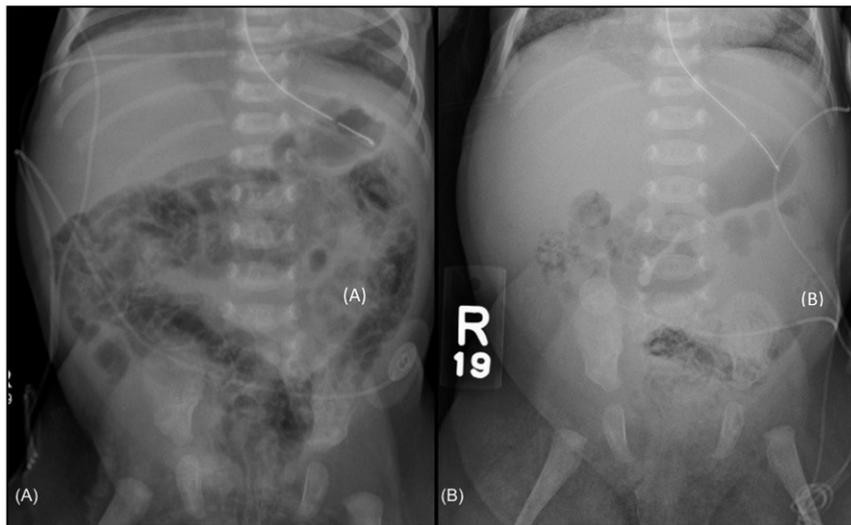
A, Abdominal radiograph on the 7th day of this infant's first course of topiramate showing mottled lucencies and pneumatosis, consistent with NEC. B, Abdominal radiograph on the 4th day of this infant's second course of topiramate, showing pneumatosis in the ascending rectosigmoid colon.
